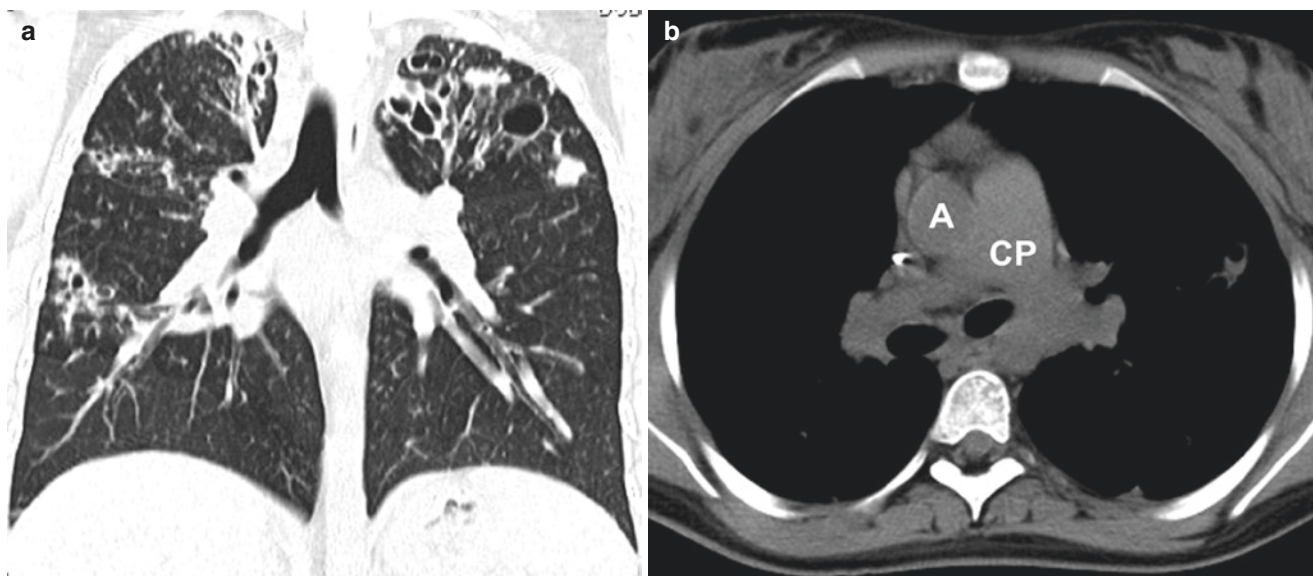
Seventeen-year-old girl with pulmonary hypertension secondary to underlying lung disease (cystic fibrosis). (a) Coronal lung window CT image demonstrates advanced lung changes secondary to
